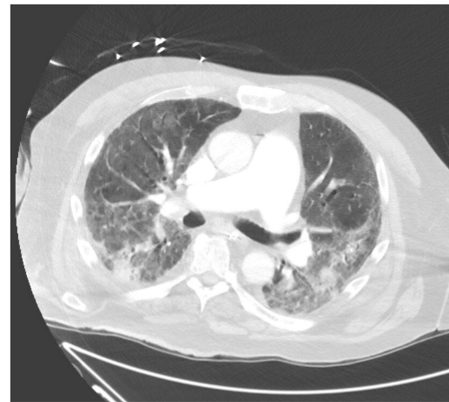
CT Chest on day 1 axial section showing infiltrates in bilateral lungs.
